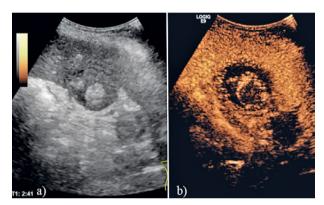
Acute cholecystitis. False tumor. Ultrasonographic exploration in grayscale (a) (mass inside the gallbladder observed around a central stone). CEUS exploration (the mass inside the gallbladder does not capture contrast agent; neoplasia is excluded) (b).
